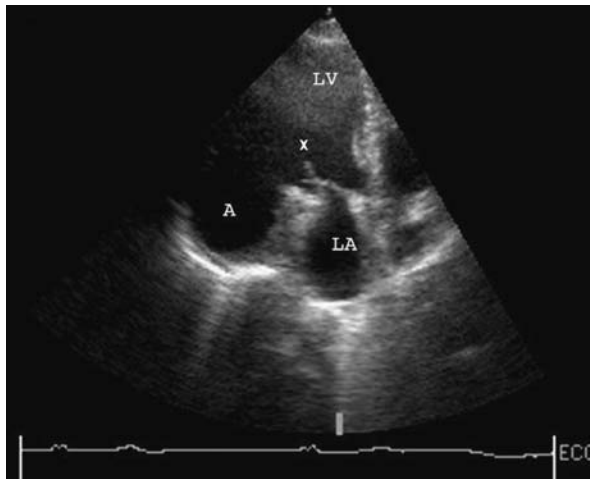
Transthoracic echocardiography shows that the posterior mitral leaflet is tethered by its papillary muscle.
